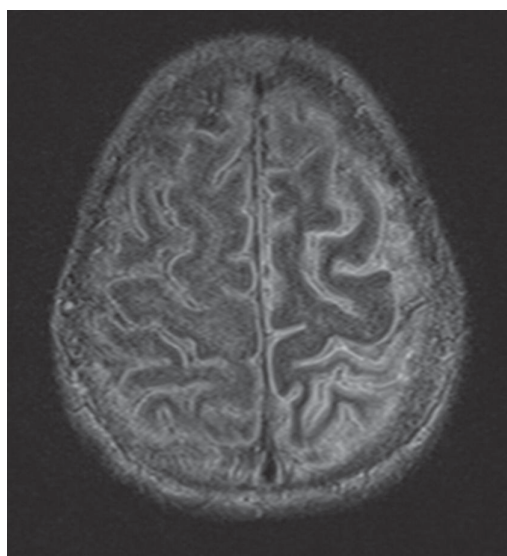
MRI image showing left parietal lobe signal intensity.
